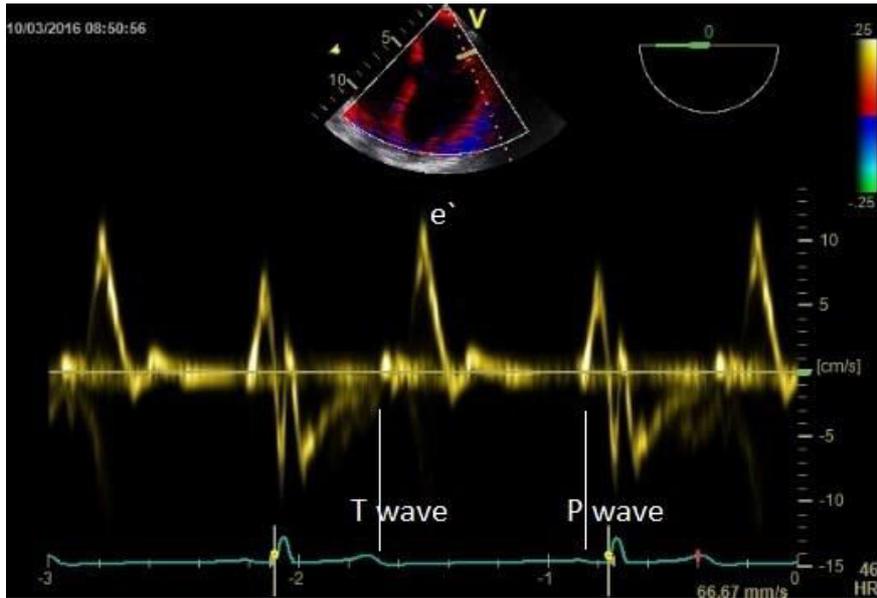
Tissue Doppler of the lateral mitral annulus
